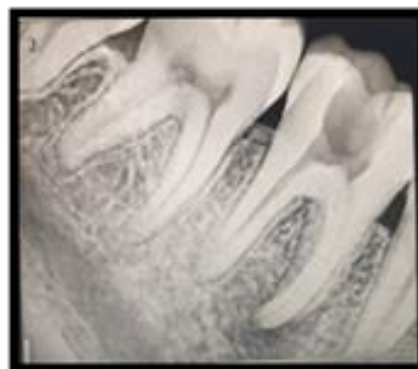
Periapical radiograph radiolucency at periapex region irt 36.
